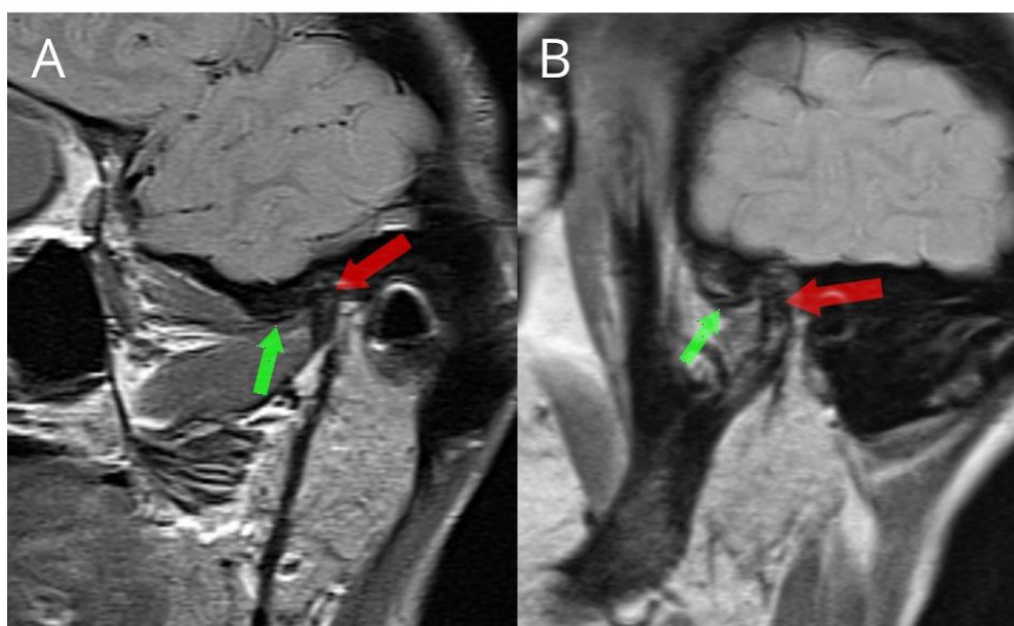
T1W MRI images showing: (A) Right TMJ with joint space reduction, fossa irregularity, subchondral sclerosis, in addition to total anterior disc displacement without reduction on the right side. (B) Left TMJ with reduced joint space, fossa irregularity, subchondral sclerosis, in addition to total anterior disc reduction. Green arrows: articular disc; Red arrows: condyle.
